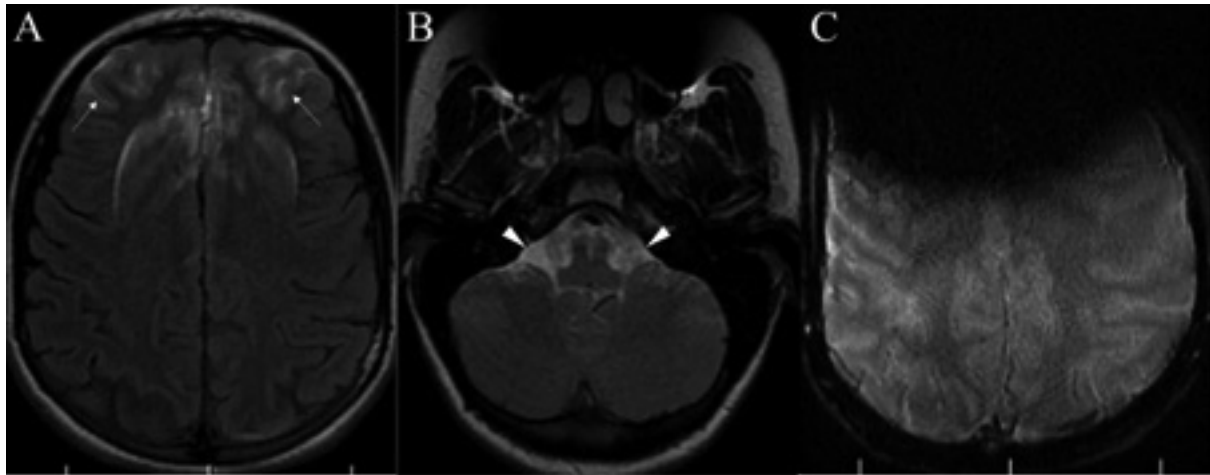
Pseudo-SAH appearance due to braces. A and B, Bifrontal sulcal (arrows) and pontocerebellar cistern (arrow heads) hyperintensities on FLAIR images. C, There is anterior cranial wide magnetic susceptibility artifact on SWI image.
